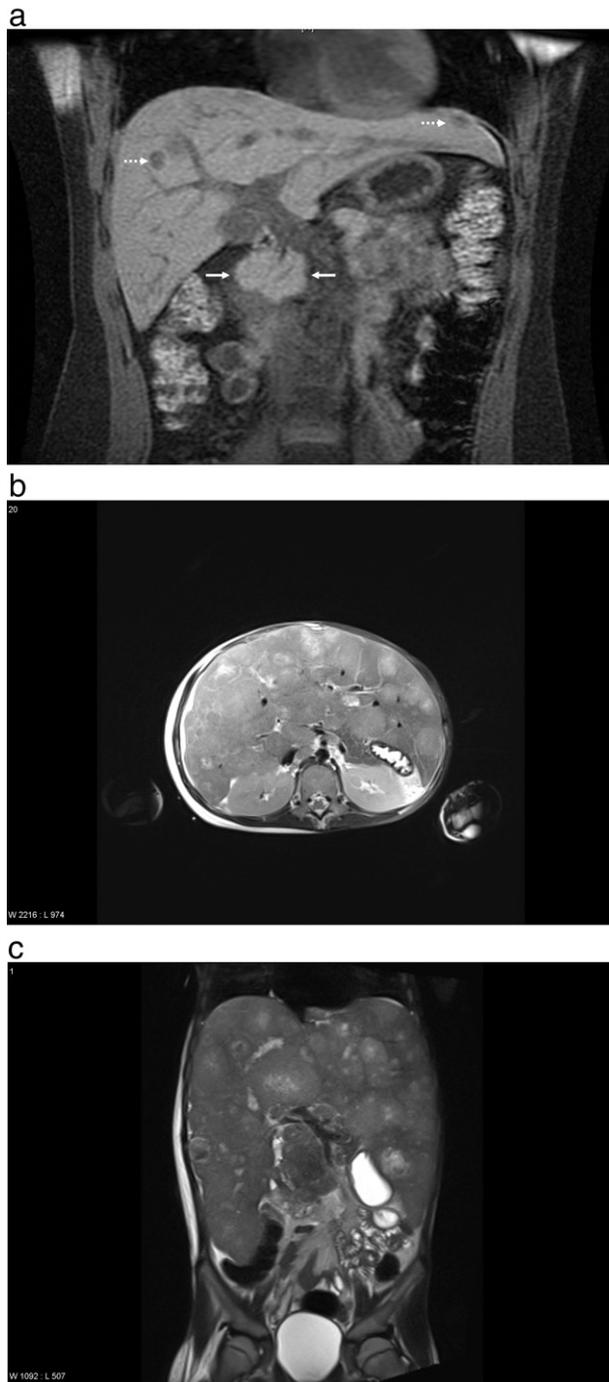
Abdominal MRI sections of Cases 2 and 3. (a) Coronal MRI section of the abdomen of Case 2 at the time of diagnosis of NEC. Note the inhomogeneous mass at the head of the pancreas (plain arrows) with hyperintensity in T2 weight and enhancement by dimeglumingadopentetat contrast medium (Magnevist). Also note the hypodense hepatic lesions (dotted arrows). (b and c) Horizontal and frontal MRI scan of Case 3. The scans show a huge abdominal mass that involves the liver and the spleen. In large parts, the borders of liver and spleen are not recognizable.
